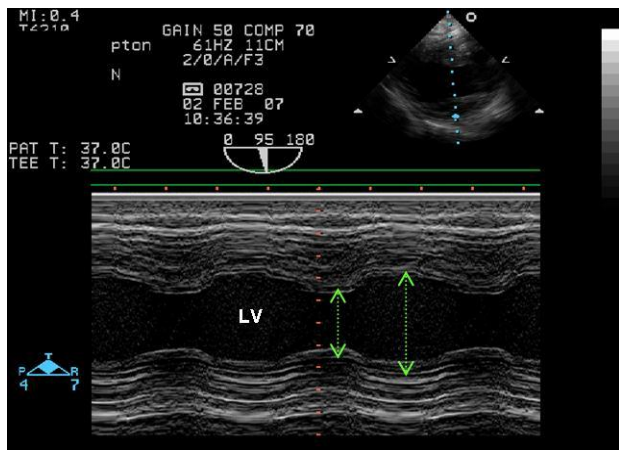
M-mode echocardiogram in a patient with severe LV impairment receiving 4 inotropic agents, and with left and right ventricular assist devices and an intra-aortic balloon pump in situ. The arrows indicate systolic and diastolic measurements for estimation of ejection fraction or fractional shortening. The LV function does not look severely compromised when the echocardiogram is regarded in isolation. Reduction in any of the mechanical circulatory support resulted in profound hypotension, worsening of M-mode parameters and VF.
